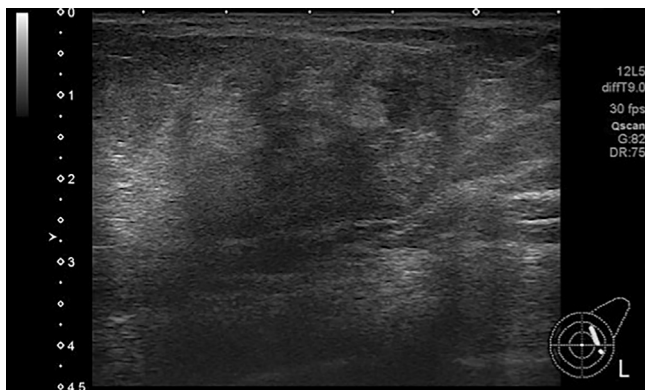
Ultrasonography, showing a well-defined mass 36 × 24 mm in size containing both hypoechoic and hyperechoic lesions.
